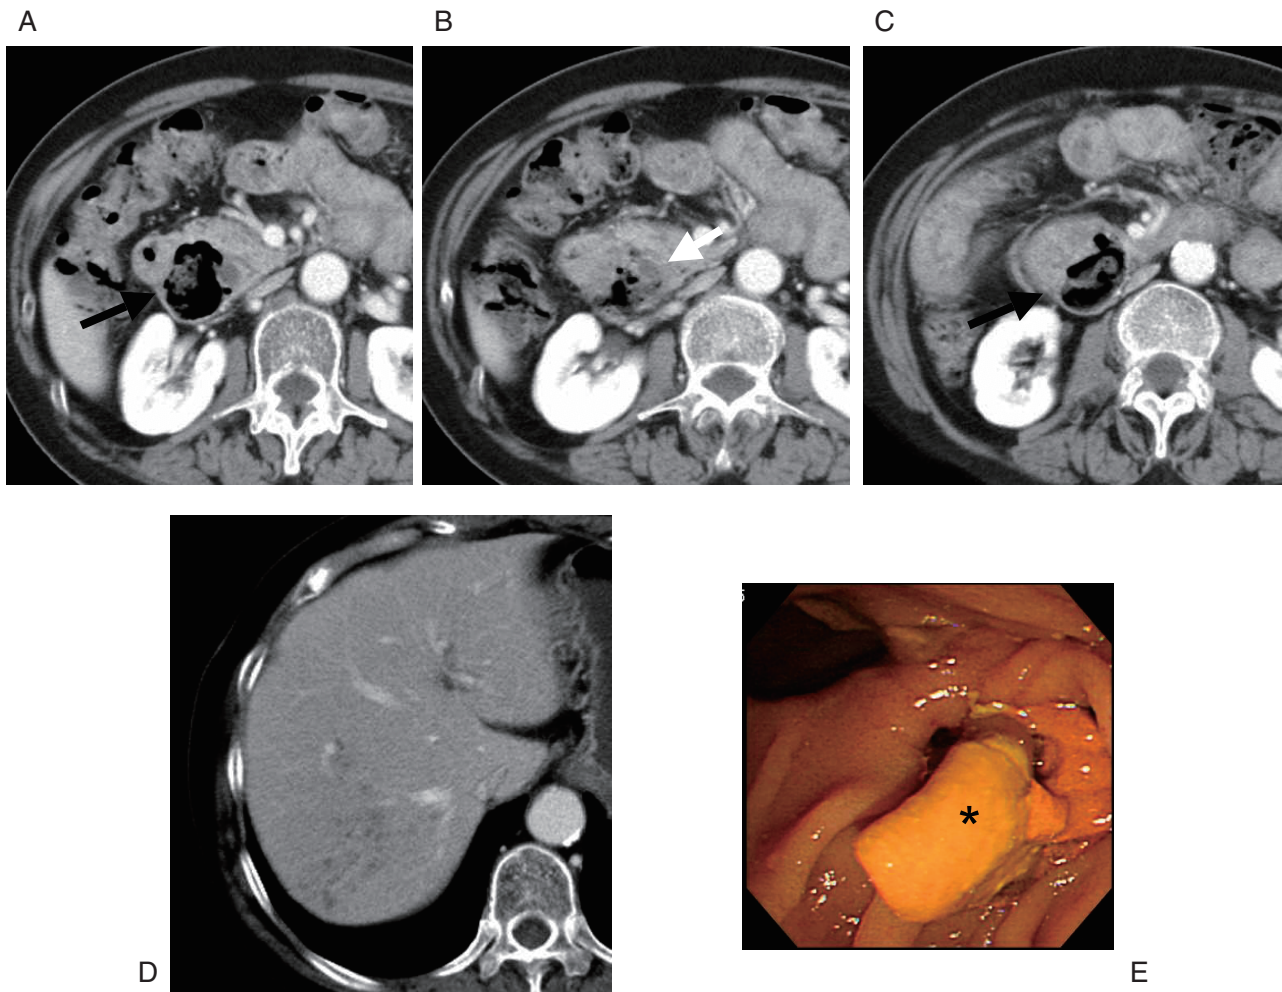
A 70-year-old man with cholecystitis, cholangitis, and liver abscess. Axial CT scans show two JPDD (black arrows: A, C) containing food debris. The common bile duct is located between the two JPDD (B). Note multiple small low-density nodules consistent with liver abscesses (D). Endoscopy reveals two JPDD containing impacted food debris (asterisk). The diverticulum on the oral side (arrowhead) was cleaned by retrieval of an enterolith and food debris (E).
